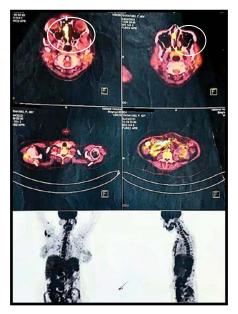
FDG PET CT showing FDG avid nasal polyp
